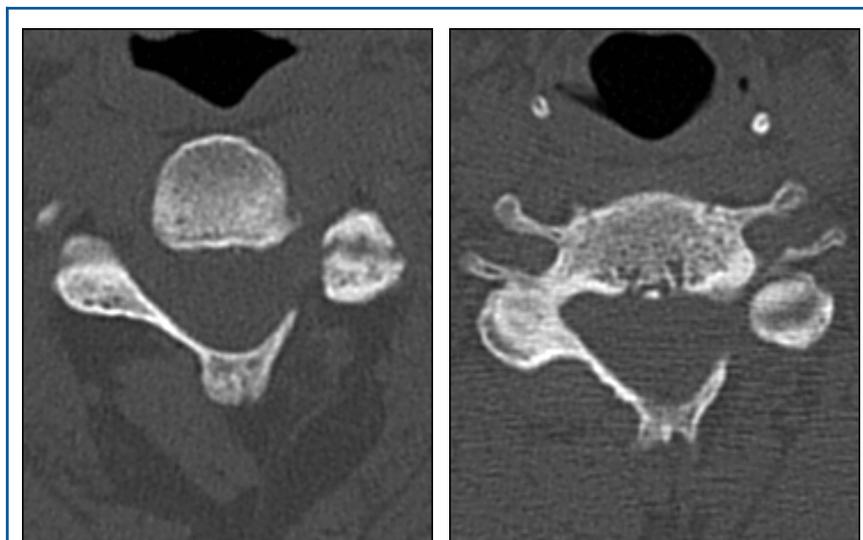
Noncontrast axial CT images showing inadequate foraminotomies which required reoperation by the authors. Left shows a C4 root foraminotomy and right a C6 root procedure, both of which are too medial, leaving persisting foraminal stenosis laterally.
